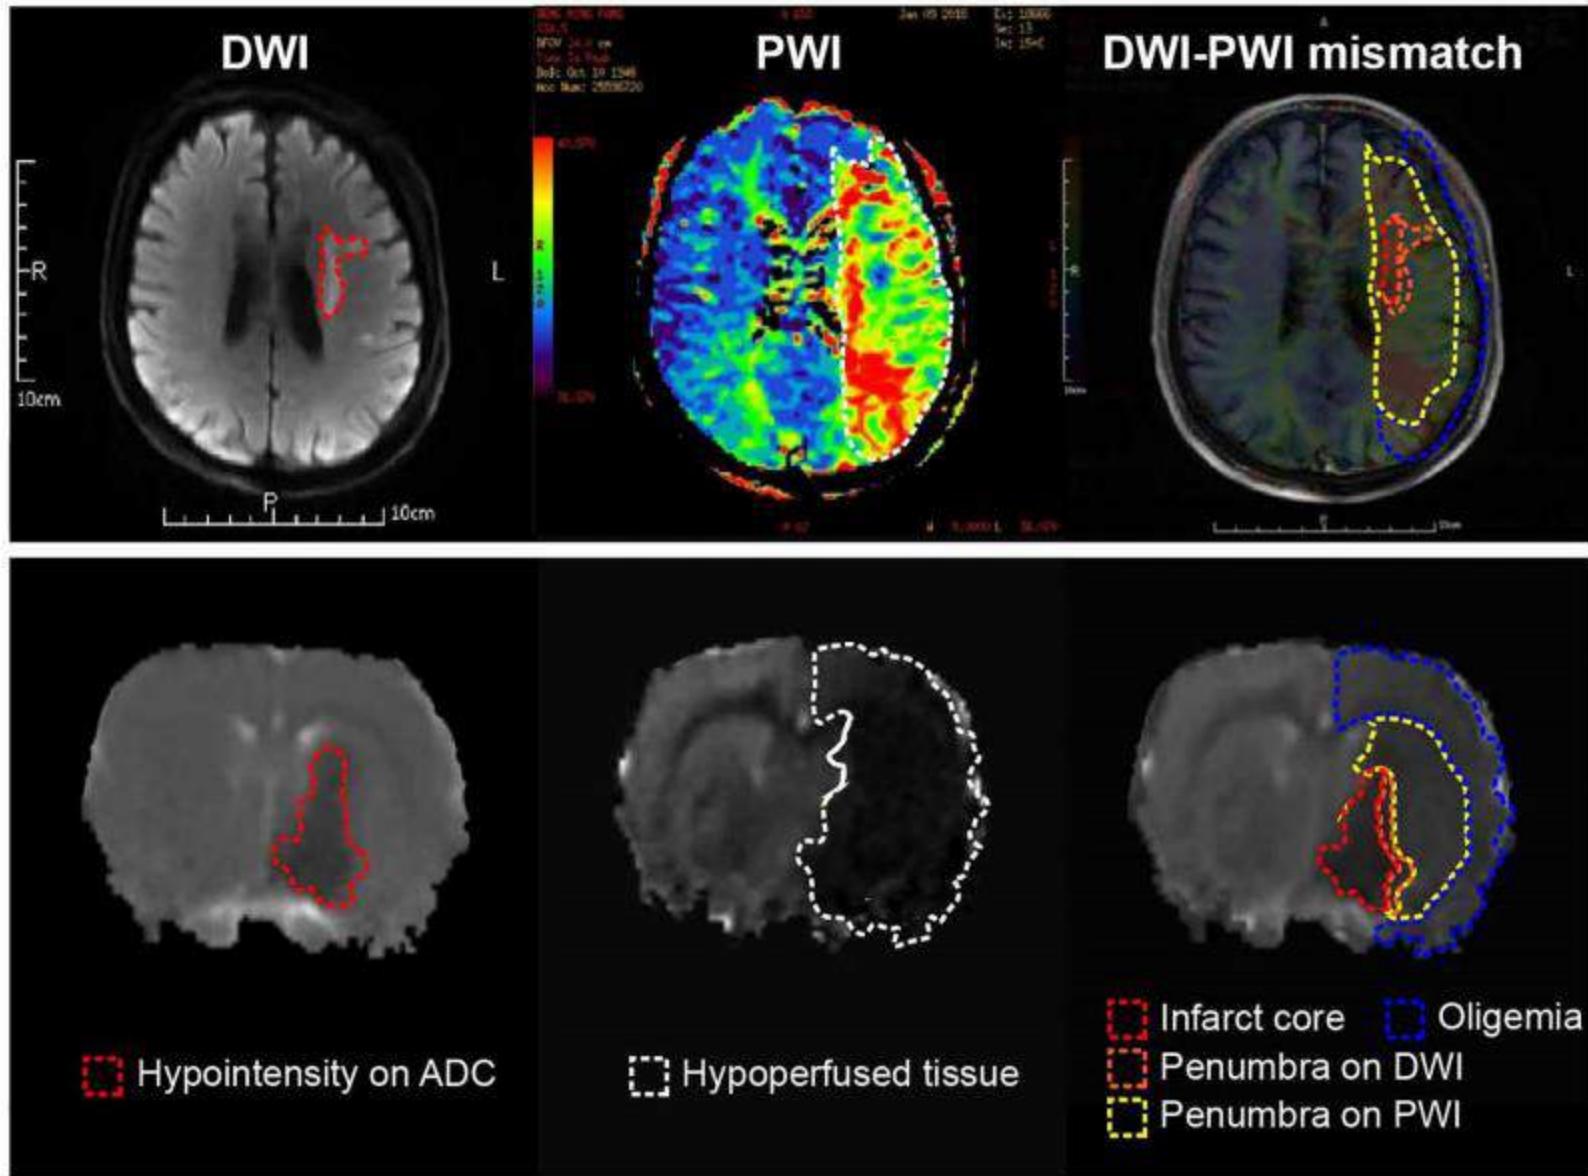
Current concept of the ischemic penumbra. Both clinical (Upper) and experimental (Below) MRI data showed early abnormality on DWI equals the infarct core plus a part of tissue at risk (penumbra), and the perfusion deficiency on PWI includes part of the region of benign oligemia. MRI, magnetic resonance imaging; PWI, perfusion-weighted imaging.
